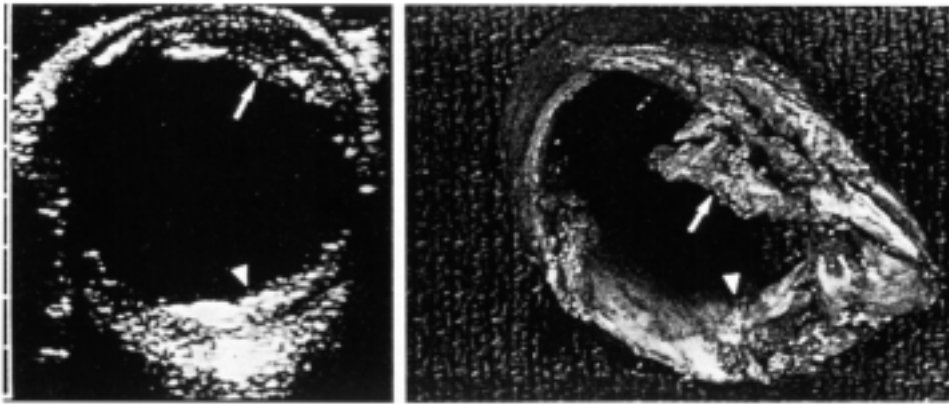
Image on the left is taken from an epiaortic ultrasound scan of the ascending aorta. The long white arrow indicates fraile plaque while the short arrow points to calcific atherosclerosis. An anatomical section from the same section of the ascending aorta after its excision and replacement by a graft. (Reprinted with permission: Davila-Roman VG, et al. *Stroke* 25:2010-6,1994.)
